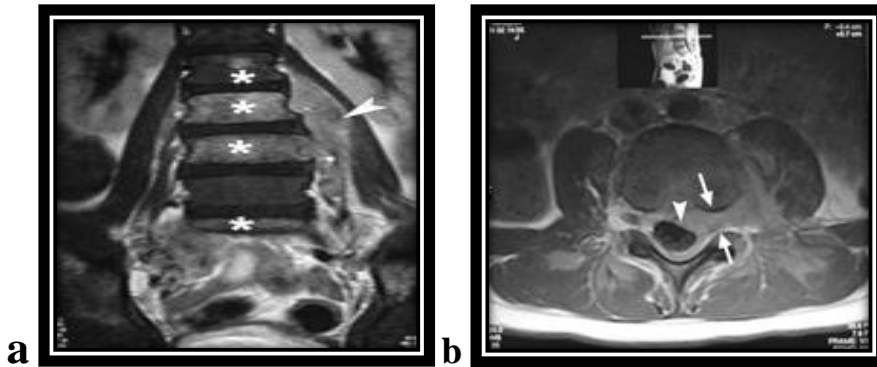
HD in a 6-year-old girl. (a) Coronal T2-weighted MR image shows a left-sided paraspinal mass (arrowhead). The second, third, and fourth lumbar vertebrae and first sacral vertebra show infiltration (*). (b) Axial contrast-enhanced T1-weighted MR image shows extension into the spinal canal (arrows) and compression of the dural sac (arrowhead) (*Toma et al., 2007*).
